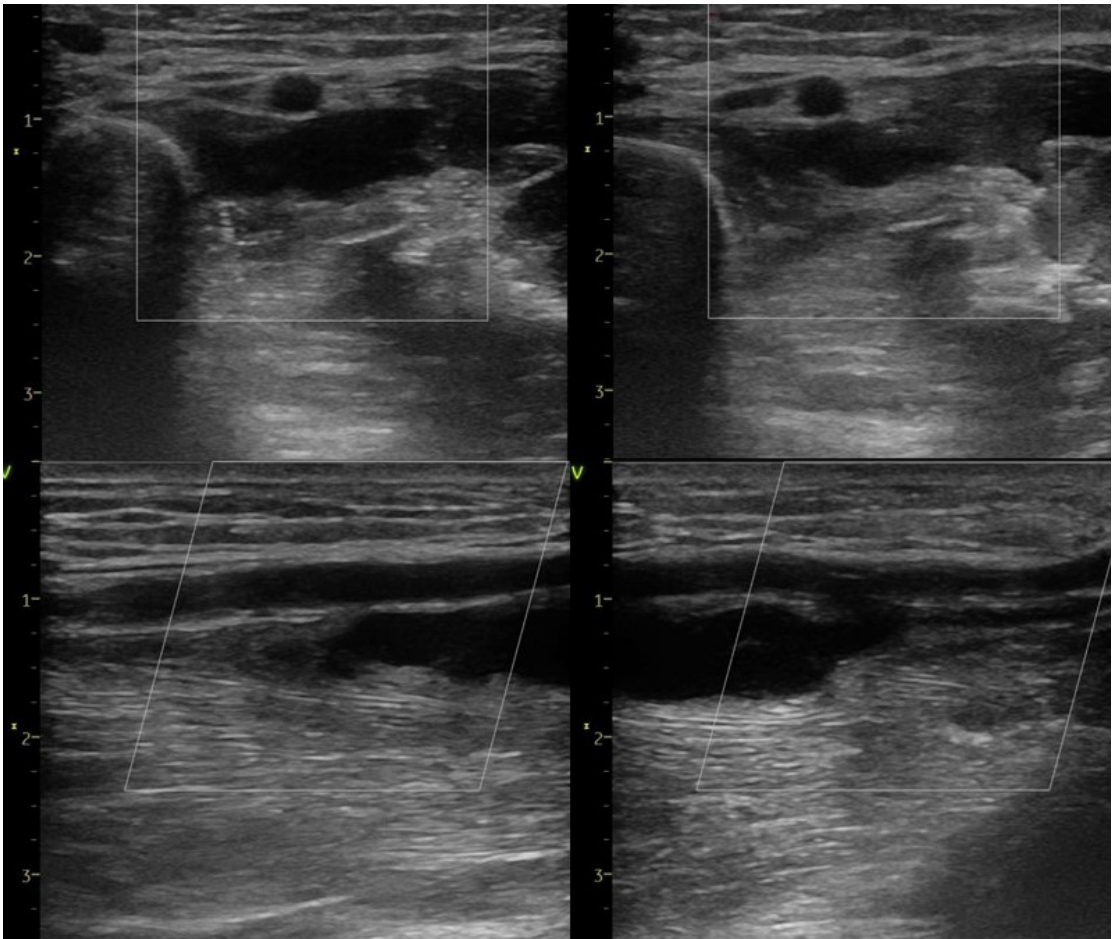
Doppler ultrasound confirmation of successful thrombotic pseudoaneurysm occlusion at forty-day follow-up.
